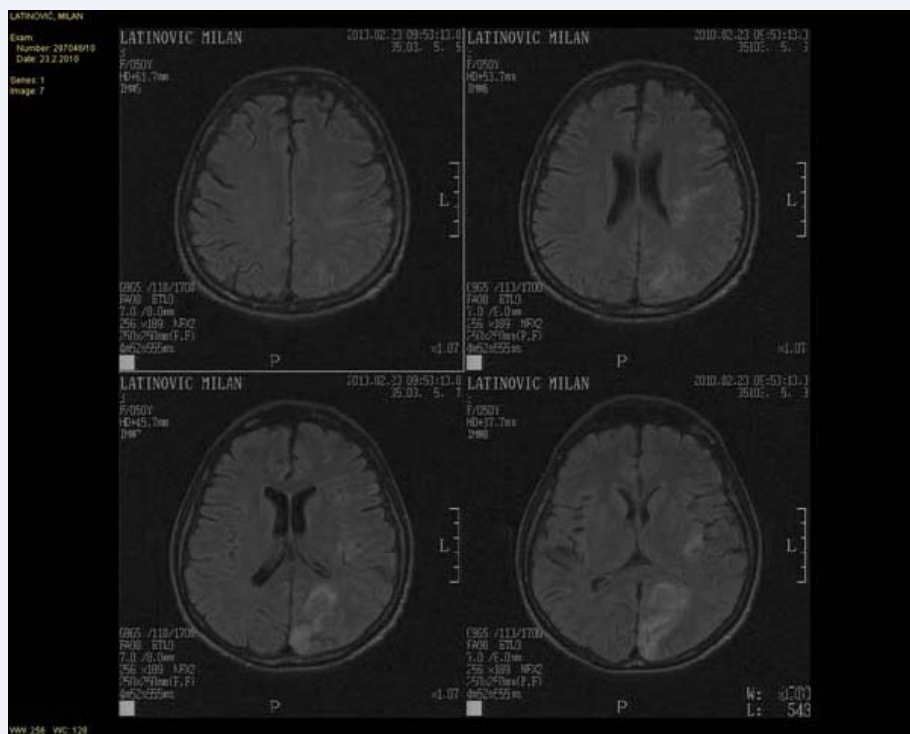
Magnetic resonance image of the brain, including an ischemic lesion of the right occipital lobe.
